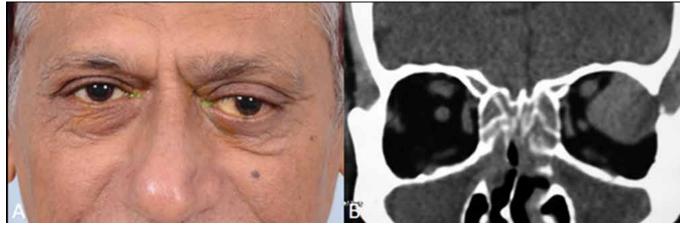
(A) Left proptosis (B) Coronal CT reveals a left supertemporal isodense orbital mass arising in the lacrimal fossa, with bony indentation and no bone destruction (apparent bony discontinuity is due to overlapping of the soft tissue mass, which was not present on axial scans, not seen in the image) which on biopsy proved to be lymphoma.
